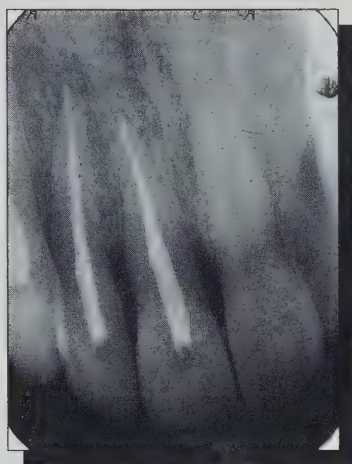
Periapical radiographs of maxillary left central incisor; a) prior to root canal therapy; and b) after root canal therapy — March 3, 1989.
